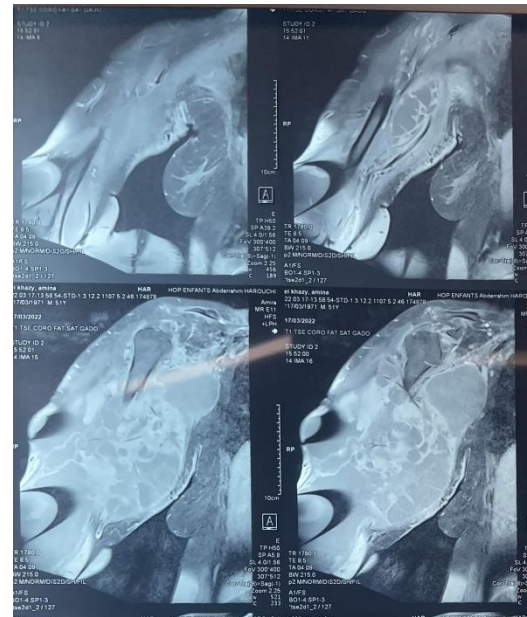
MRI showing expansion of tumor process
